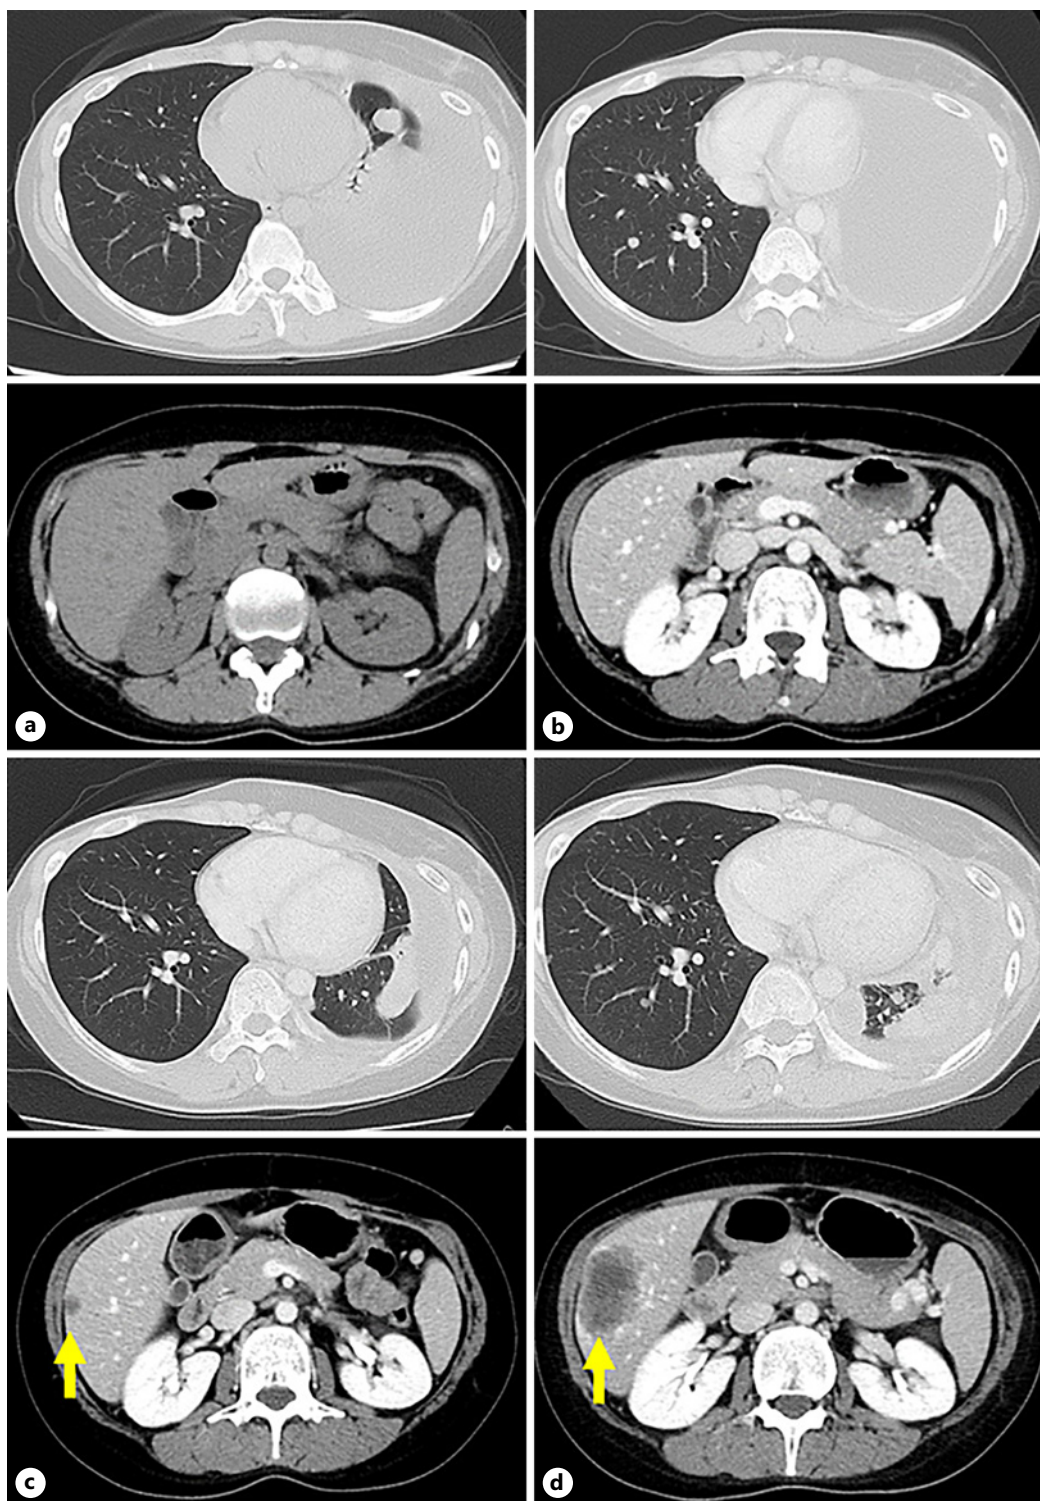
Computed tomography images showing lung metastases, pleural dissemination, pleural effusion, and liver metastasis during the course of treatments. a Before the administration of atezolizumab plus nab-paclitaxel. b After 4 months of treatment with atezolizumab plus nab-paclitaxel. c After 4 months of treatment with olaparib. d After 2 months of treatment with pembrolizumab plus gemcitabine plus carboplatin. The arrow indicates liver metastasis.
